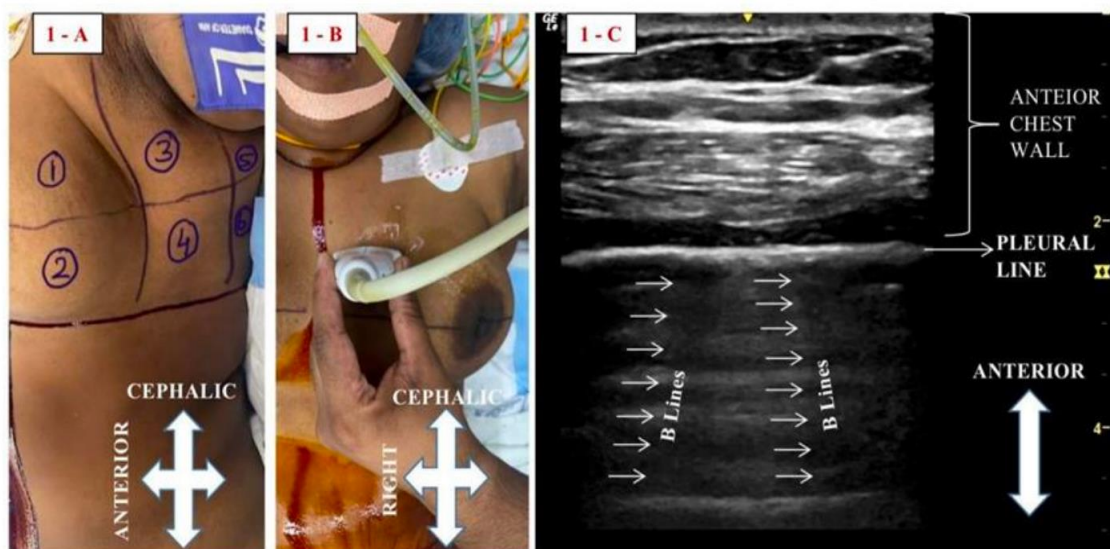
A) Six areas for scanning in patient's hemithorax, B) Final Ultrasound probe position, and C) Lung Ultrasound images obtained for LUS assessment (white arrows depicts the vertical B lines)
